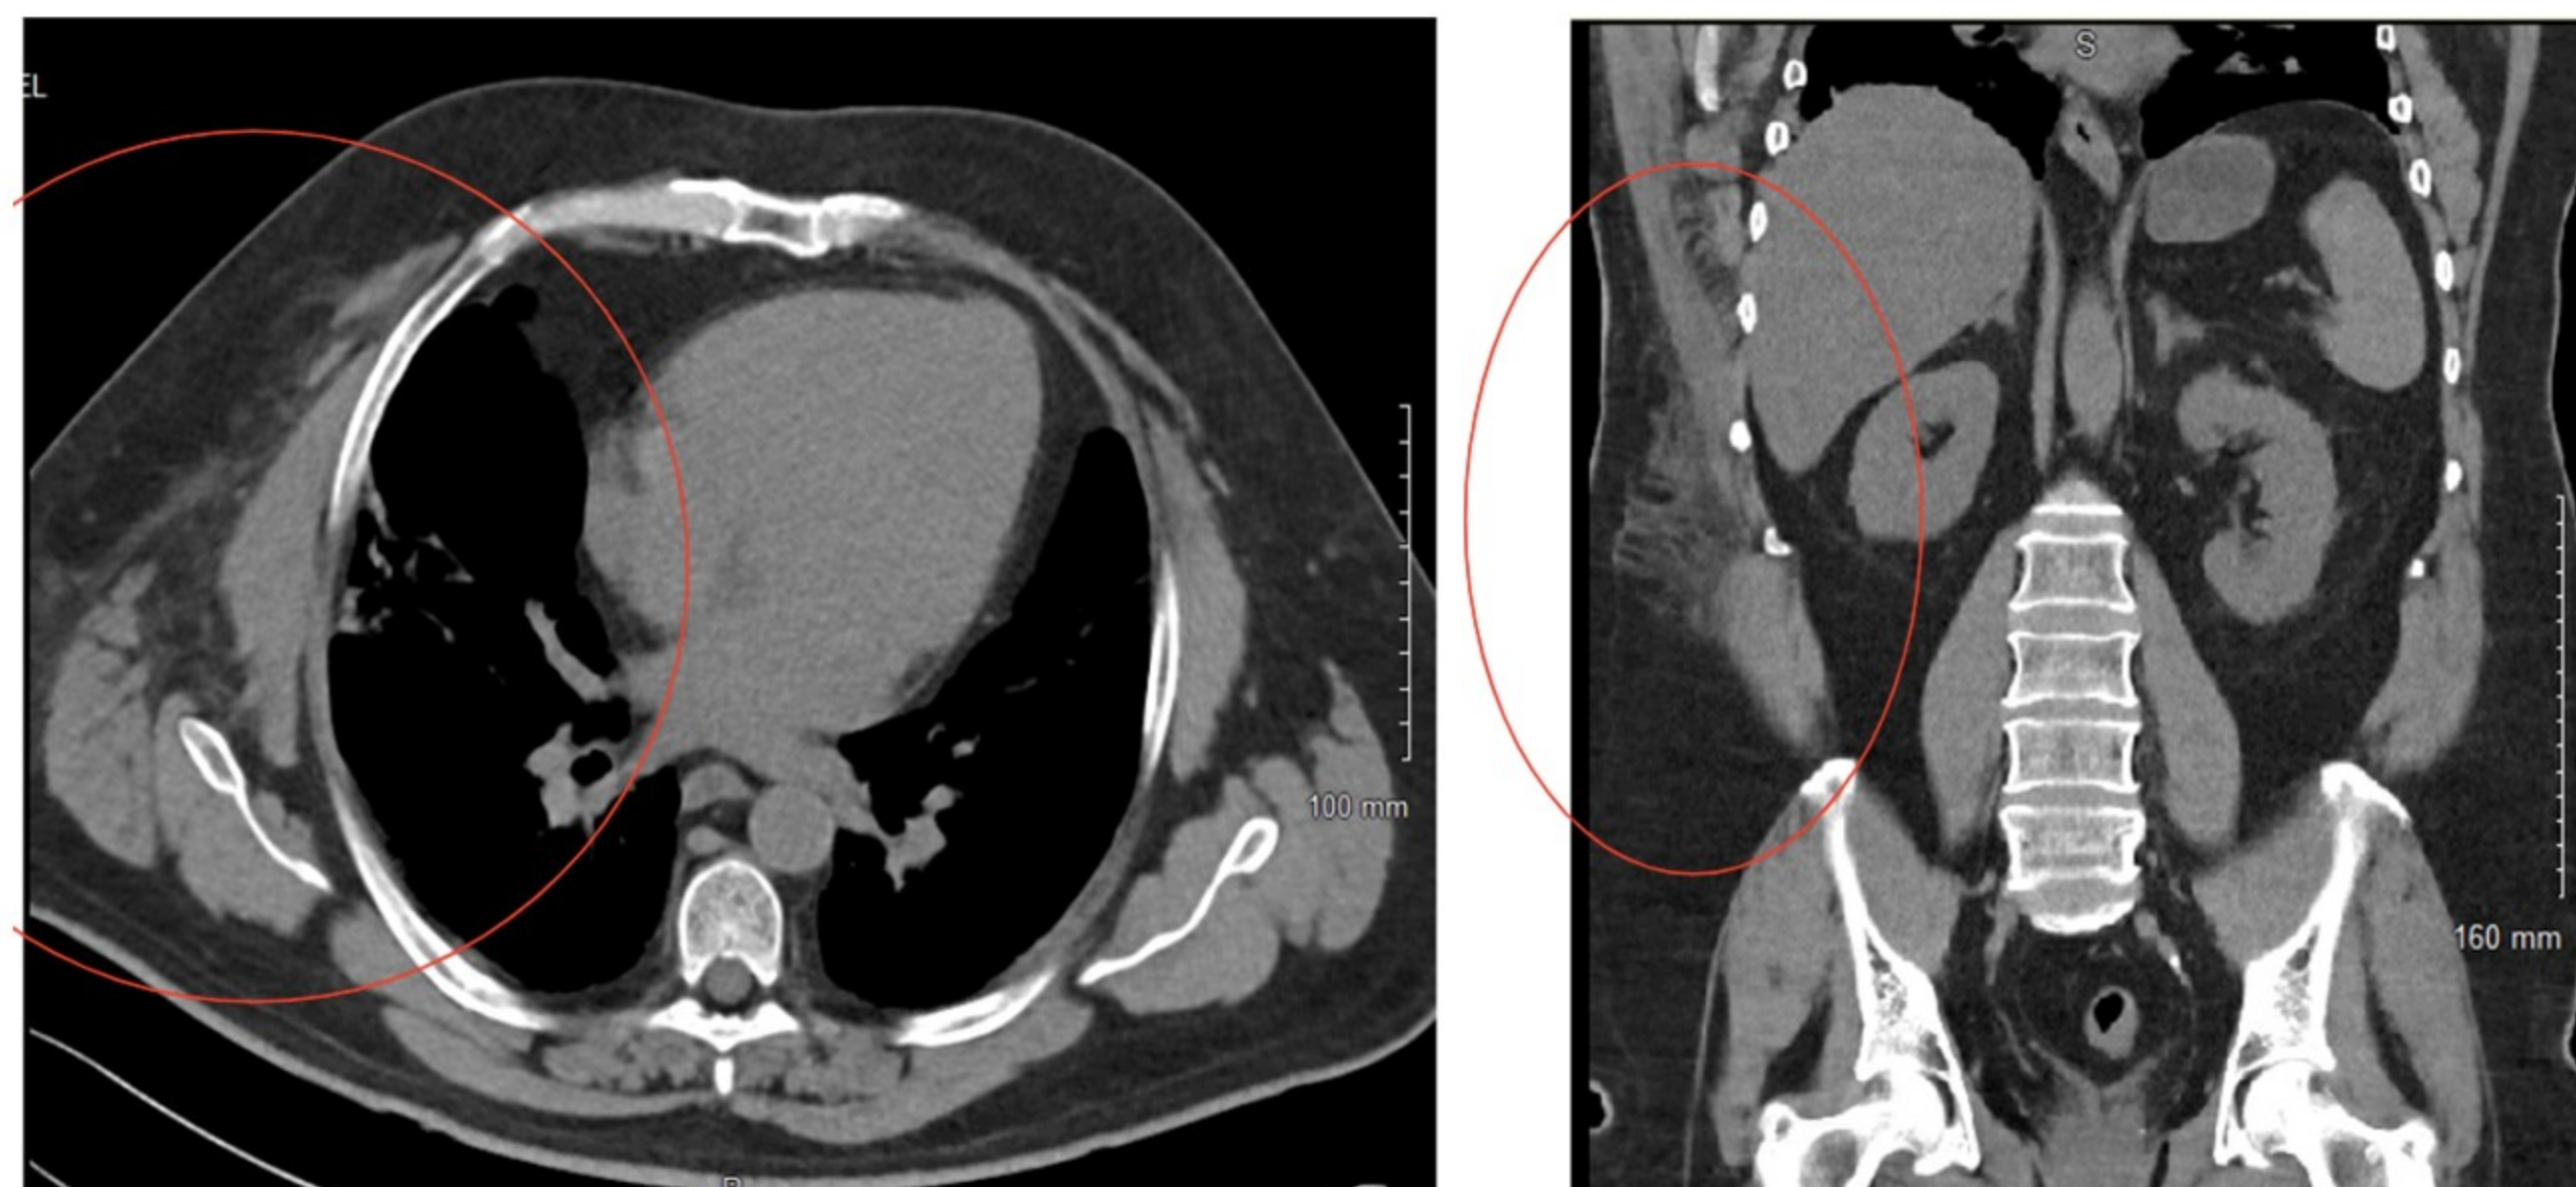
Sagittal and coronal views of CT imaging demonstrating local soft tissue edema.
